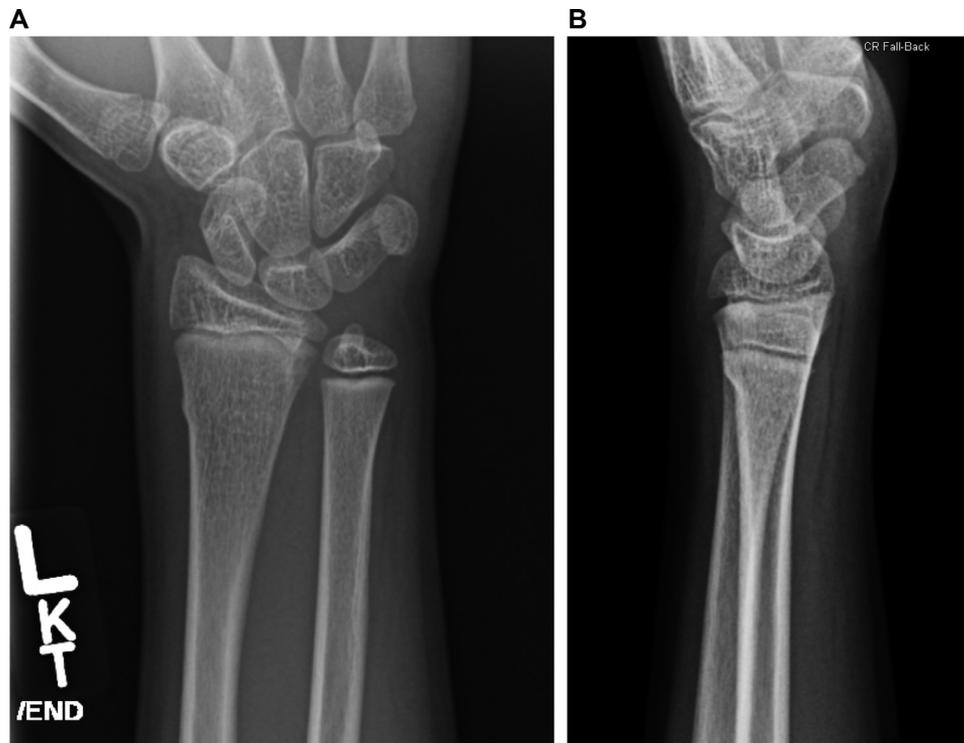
AP (A) and lateral (B) radiographs depicting a stable distal radius buckle fracture. On AP imaging, there is a “buckling” of the metaphyseal cortex. On the lateral image, there are 2 points of inflection. This patient would receive a Velcro brace at our institution, without formal follow-up.
